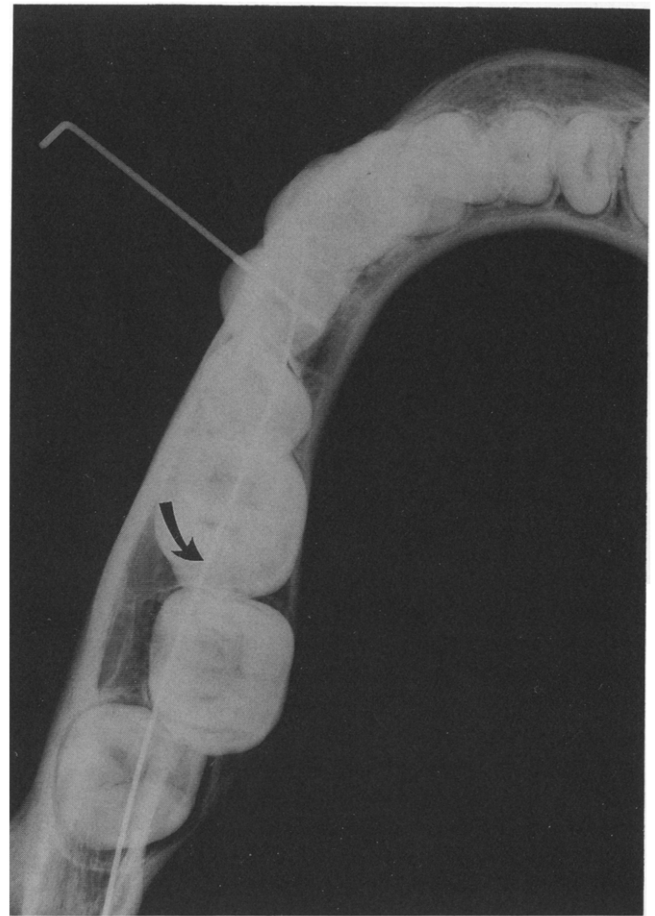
Radiograph showing a typical S-shaped pathway of the mandibular canal as demonstrated by the insertion of a wire (arrow) into the mandibular foramen.
